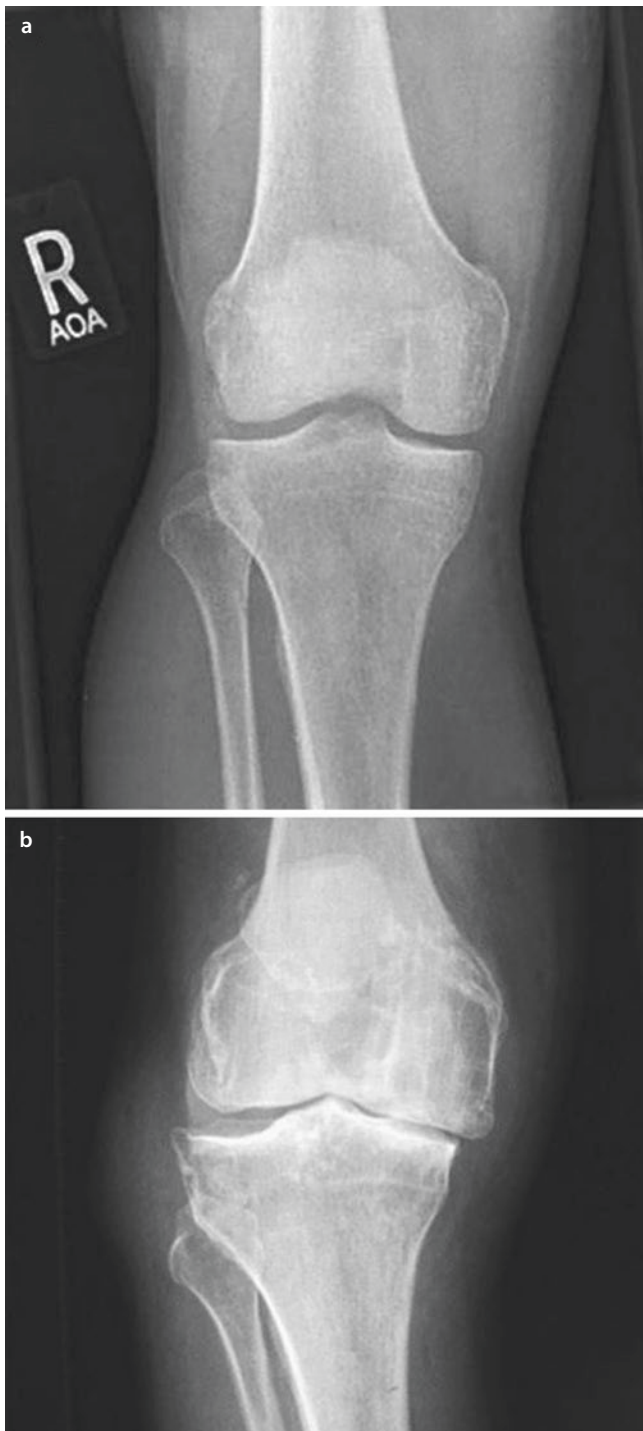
a Normal radiograph of the knee. (From Abdul-Jabar HB, et al. Primary meningococcal oligoarthritis of the knee—case report and review of the literature. *Eur Orthop Traumatol.* 2011;2:149. ► <https://doi.org/10.1007/s12570-011-0078-2>. Reprinted with permission Springer Nature). b Arthritic knee. (From Leonard M, Murphy PG. End-stage osteoarthritis of the knee presenting with foot drop. *Eur J Orthop Surg Traumatol.* 2007;17:399. ► <https://doi.org/10.1007/s00590-007-0200-x>. Reprinted with permission from Springer Nature)
